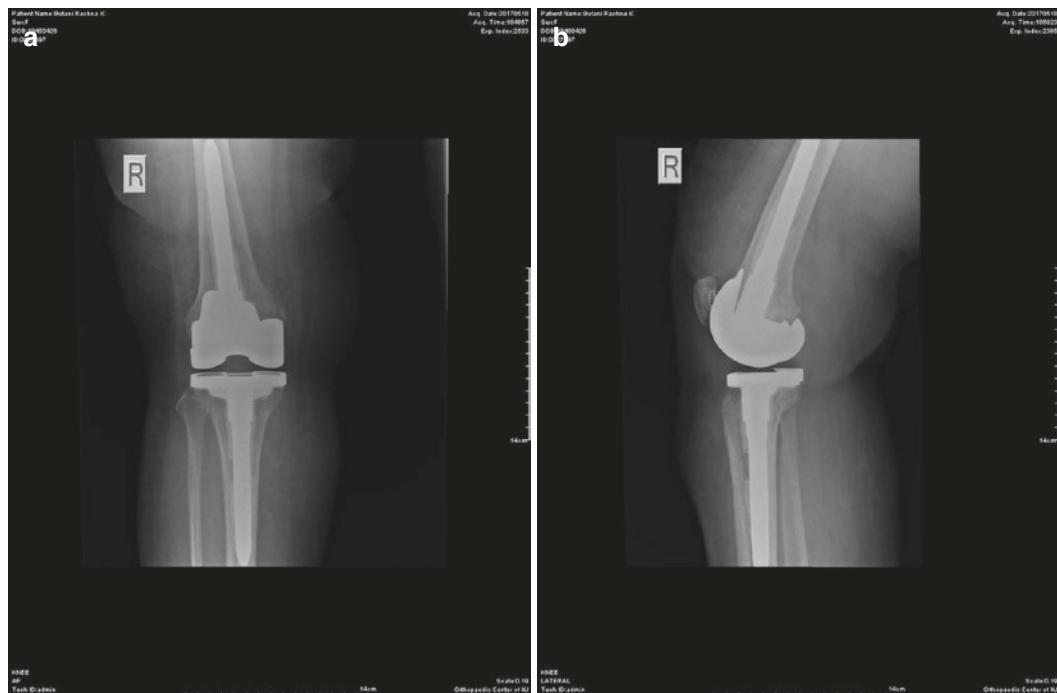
The postoperative anteroposterior and lateral X-rays of the patient in Fig. 2.26, showing the total knee arthroplasty with intramedullary stems in good alignment
